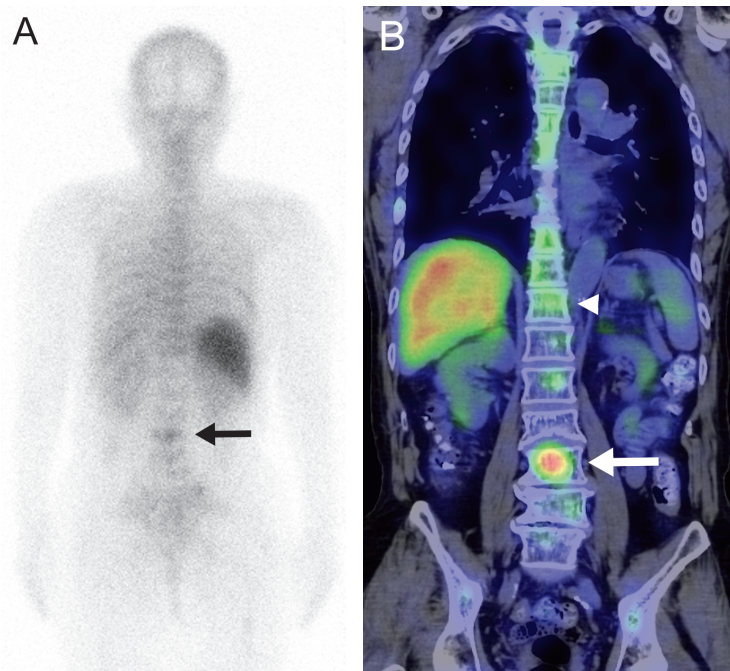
$^{111}\text{In-Cl}_3$ scintigraphy with single-photon emission computed tomography/computed tomography (SPECT/CT) findings. The posterior planar (A) and SPECT/CT (B coronal) scintigraphy images showing abnormal increase in tracer uptake in the L3 vertebra (arrows) and subtle uptake in the other vertebrae (arrowhead). The $^{111}\text{In-Cl}_3$ uptake pattern detected by SPECT/CT was similar to the $^{18}\text{F-FDG}$ uptake pattern corresponding to the bone lesions on MRI.
